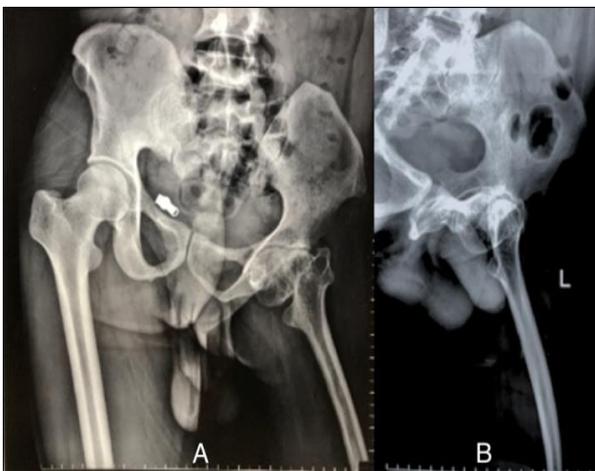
Radiographs showing a stenotic femoral canal on the left side. Also note the pelvic obliquity. A: antero-posterior view; B: frog-leg lateral view.
